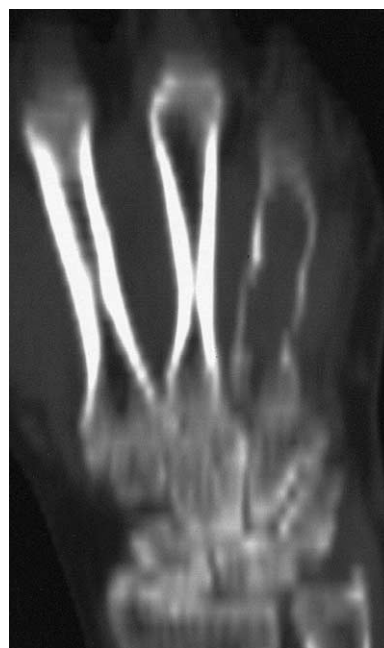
Preoperative anteroposterior x-ray film of the left fourth metacarpal showing a radiolucent tumor causing an expansion of the whole metacarpal with marked cortical thinning.
